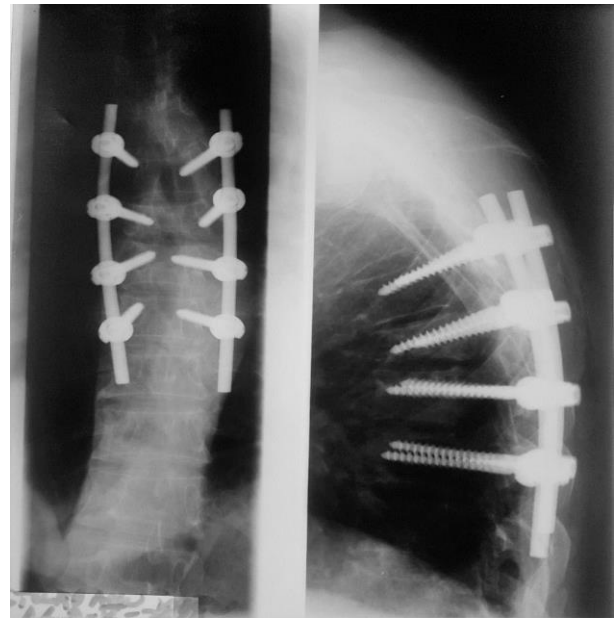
Postoperative radiographic control: stabilization with 8 transpedicular screws and 2 titanium rods (personal collection).
